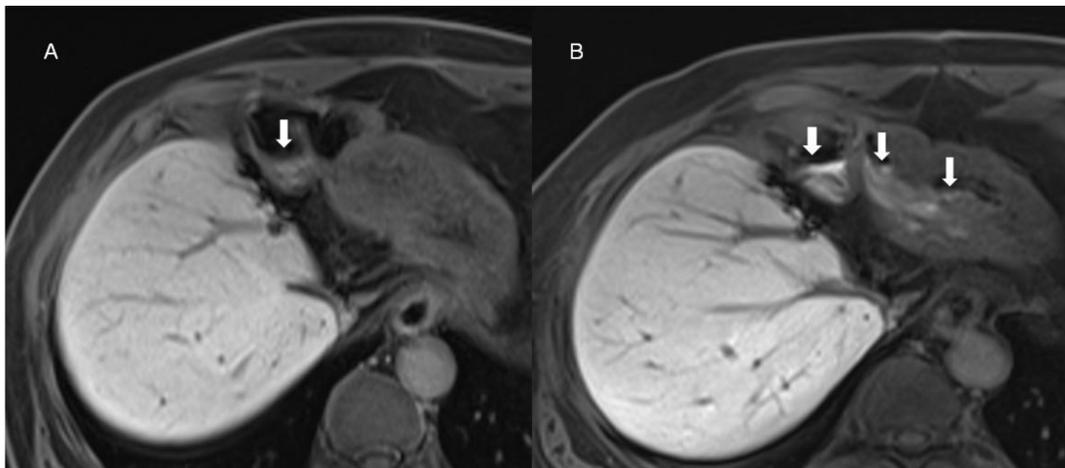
Axial gadoxetic-acid enhanced T1-weighted MR images of a 58-year-old male patient. Duodenogastric reflux (arrows) into the gastric antrum in the hepatobiliary phase (A) and into the gastric corpus (in the delayed phase (70 min after injection) (B). Upper endoscopy revealed erosive gastritis but no bile reflux. Biopsy proved chemical gastritis
